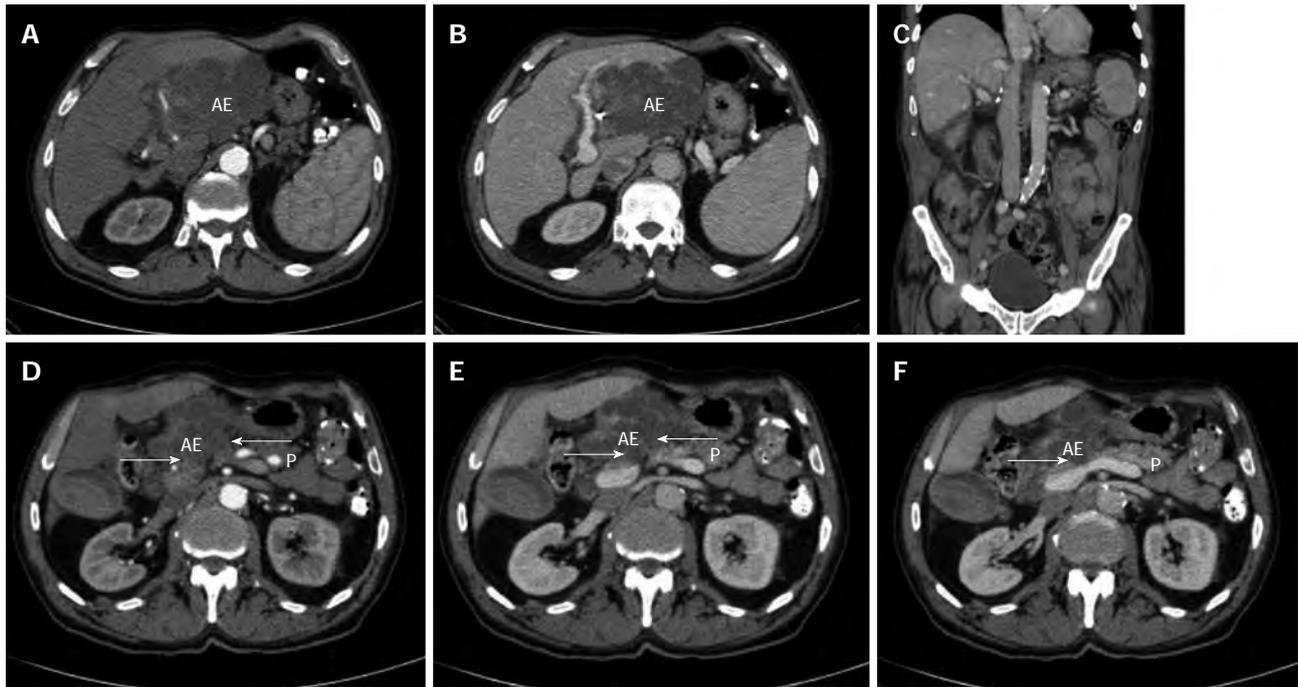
Radiological findings prior and after curative resection. A, B: Computed tomography of the abdomen displaying an extended tumour manifestation prior to resection; C: Computed tomography of the abdomen following extended left hemihepatectomy; D-F: Computed tomography of the abdomen prior to resection. Arrows: possible extensive adhesions to adjacent pancreatic head and corpus. AE: Alveolar echinococcus tumour; P: Pancreas.
